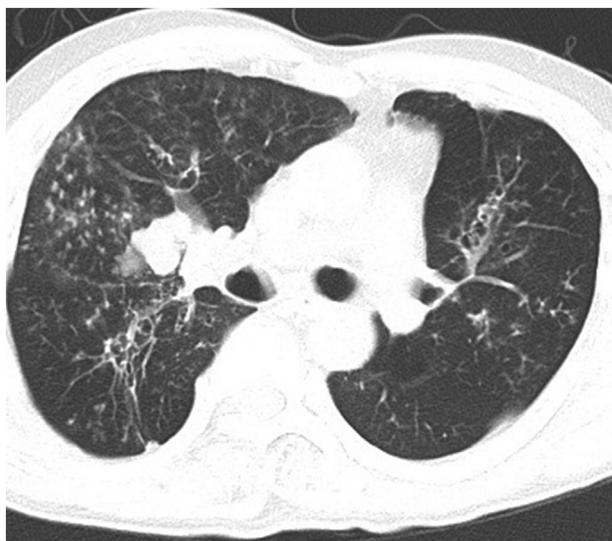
Chest computed tomography obtained at the time of diagnosis of allergic bronchopulmonary aspergillosis.
